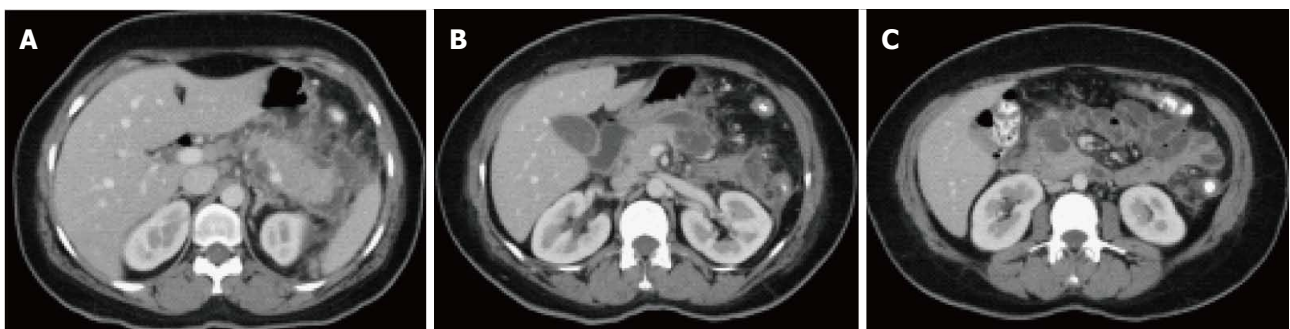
Peripancreatic fluid secondary to multifocal acute necrotizing pancreatitis. A-C: Axial CT images during the late arterial phase. There are two areas of focal necrosis involving the pancreatic body (B) and pancreatic head/uncinate process (C), associated with loculated peripancreatic fluid collection (A).
